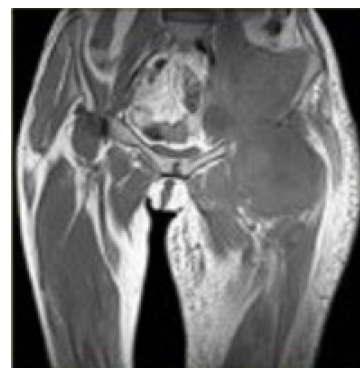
MRI (Stir) Coronal section after five cycles
